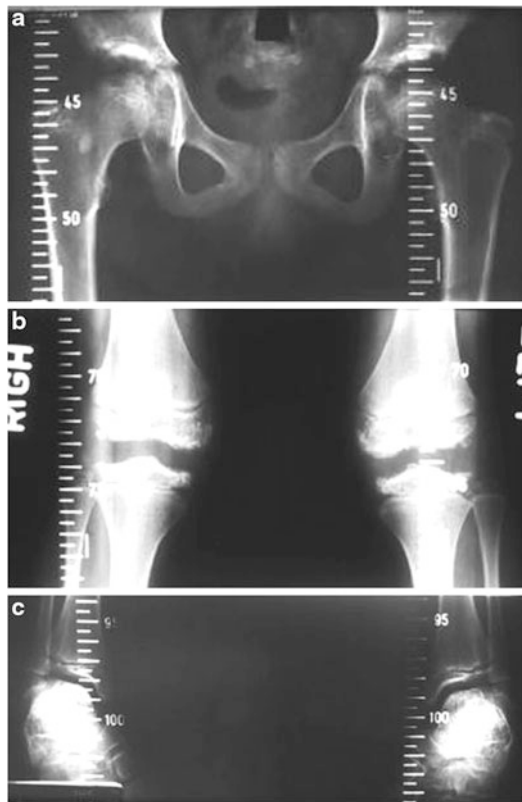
(a–c) Radiographs of another patient with multiple epiphyseal dysplasia showing poorly formed acetabular fossae, poorly ossified femoral heads (a), and flattened epiphyses of the knees (b) and ankles (c)
